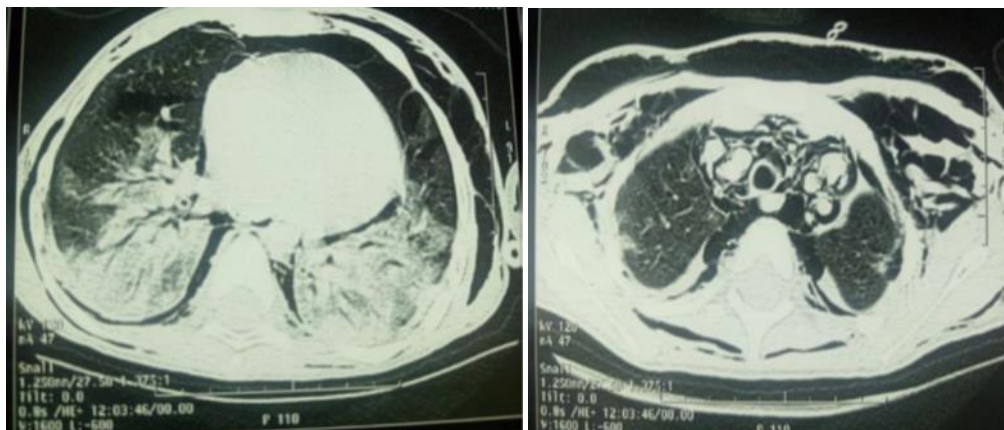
Chest CT: Pneumomediastinum, bilateral pneumonia and subcutaneous emphysema.
